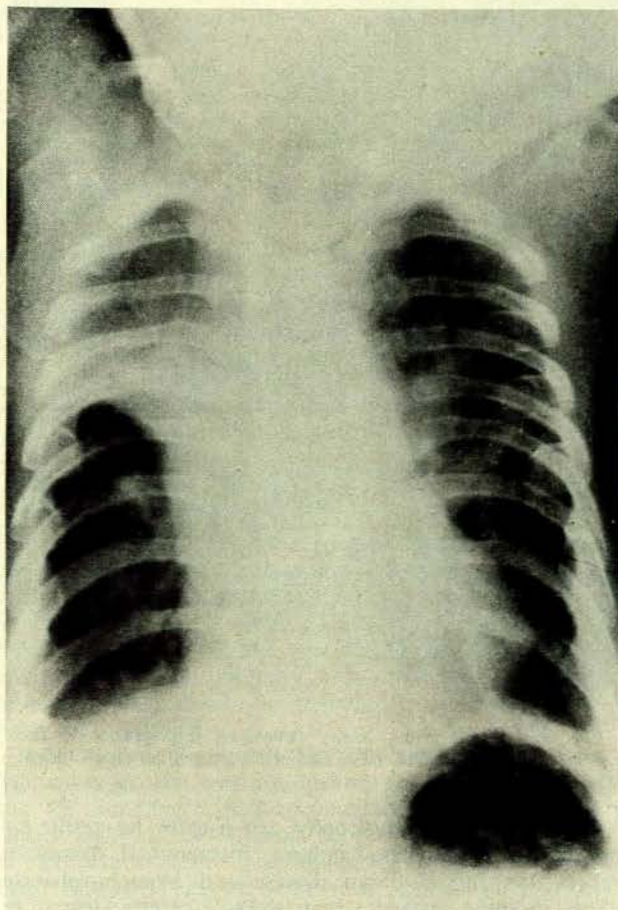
Chest X-ray showing, in addition to pulmonary pathology, the characteristic narrow thorax and abnormally high clavicles.
